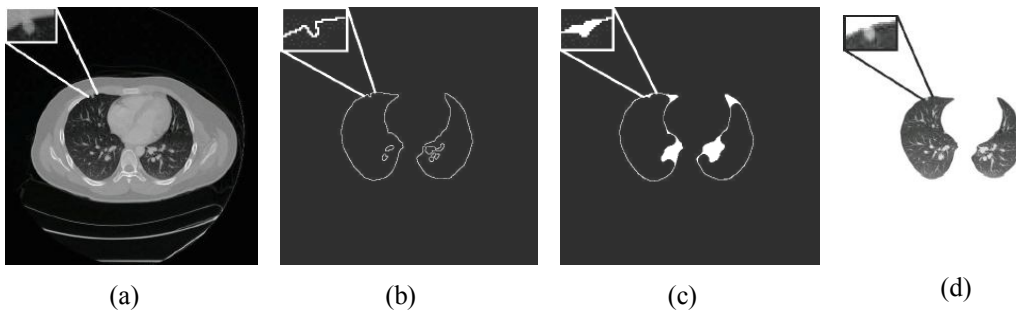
(a) Original HRCT image (b) Segmented lung boundary (c) Smoothed lung boundary (d) Segmented lung regions [21]
